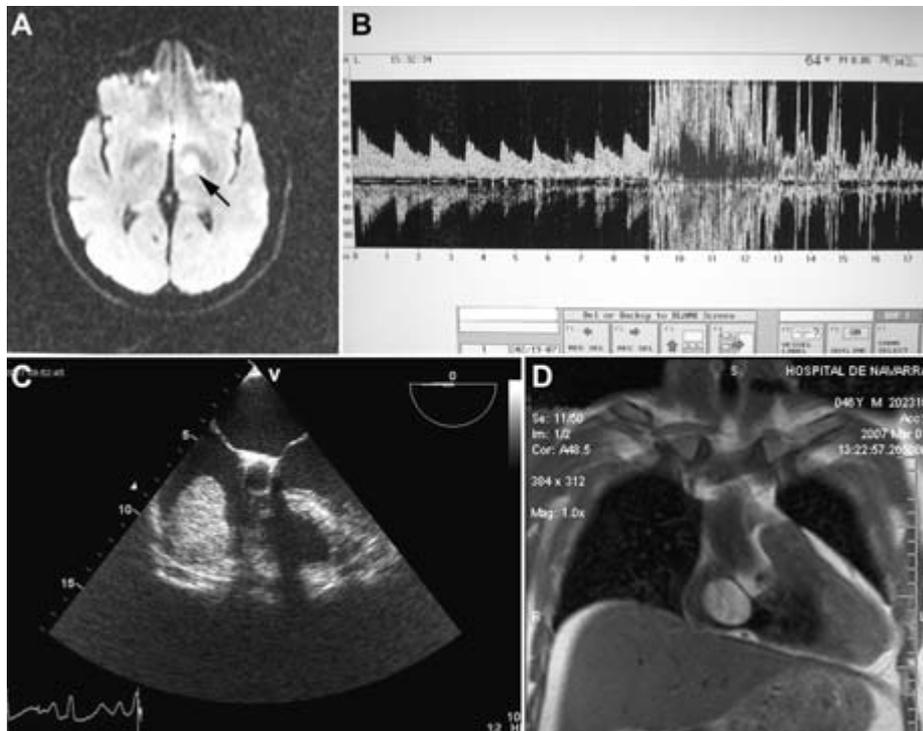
A, Axial diffusion-weighted cranial resonance image showing increased signal intensity in the left anterior thalamus (arrow) suggestive of an acute infarction. B, Contrast saline transcranial Doppler ultrasound (bubble test) using the Valsalva manoeuvre showing a high number of microembolic signals in the left medium cerebral artery indicative of a right to left shunt. C, Transesophageal echocardiogram showing a hyperechoic mass attached to the free wall of the right atrium. D, Cardiac resonance image, T1-weighted sequence, showing a strongly hyperintense lesion in the right atrium, suggestive of a lipoma.
